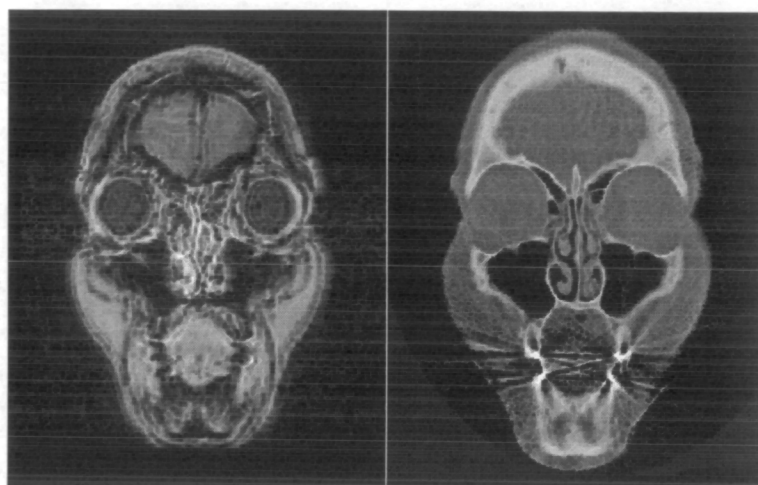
Example coronal slices through MR (left) and CT (right) images of patient F containing artefacts due to the presence of metal in the fillings of teeth.
